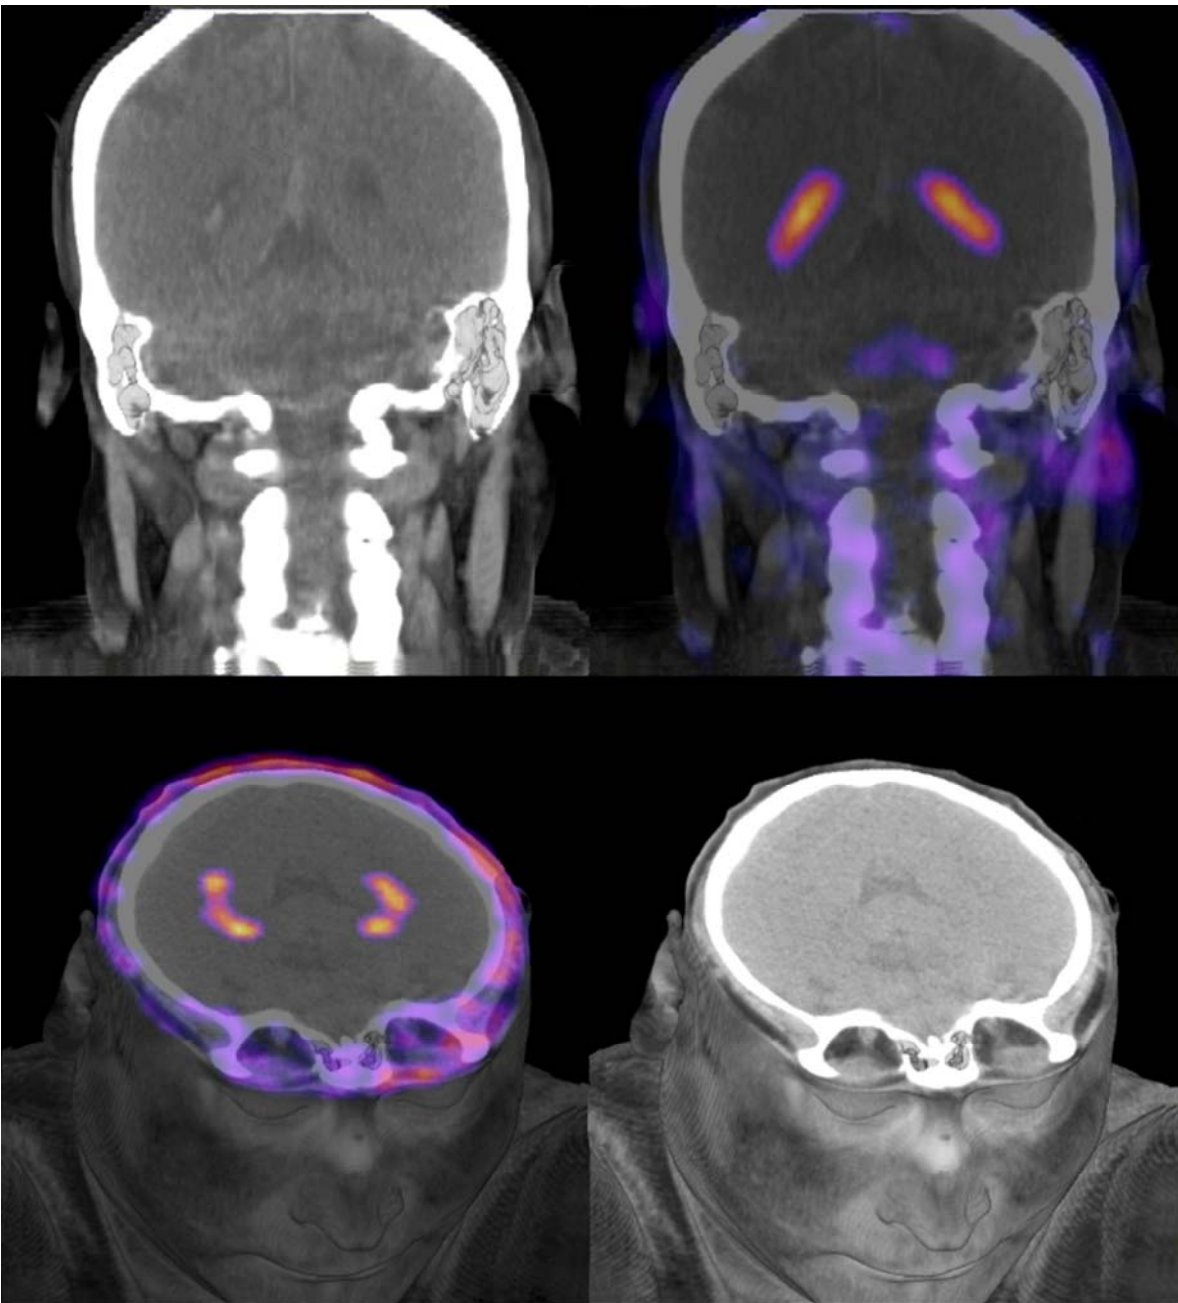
PET/CT and CT images showing the normal uptake of ^{68}Ga -DOTA-E-[c(RGDfK)]₂ in choroids plexus at the supratentorial ventricular system.
